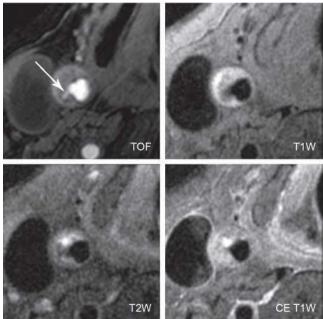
Multicontrast MR images demonstrating rupture of fibrous cap in a carotid artery plaque (arrow). High signal intensity in T2-weighted and postcontrast TI-weighted images indicates plaque inflammation and neovasculature. (Modified from Chu B, Ferguson MS, Chen H, et al: Cardiac magnetic resonance features of the disruption-prone and the disrupted carotid plaque. JACC Cardiovasc Imaging 2:883, 2009.)
